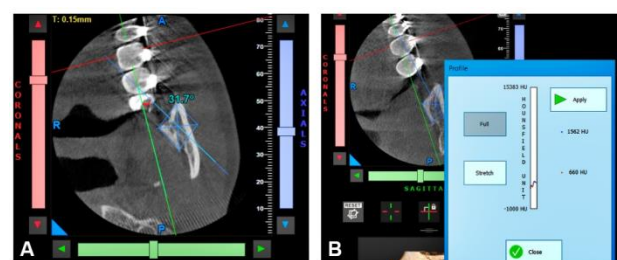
Evaluation of insertion angulation and cortical bone density on CBCT scans: (A) Modified N-Angle and (B) Cortical bone density using trace profile
